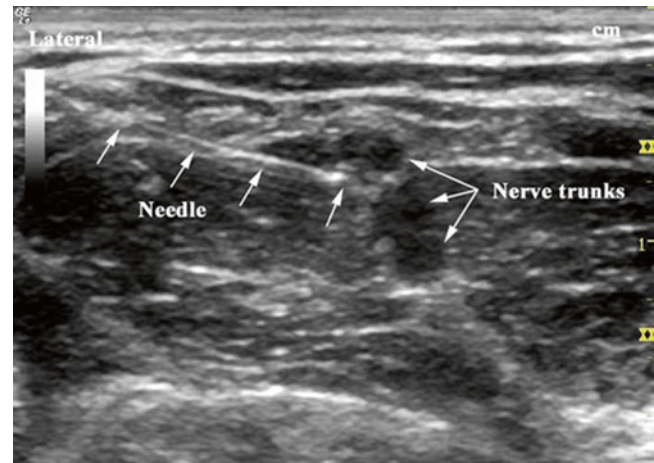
In-plane needle placement during ultrasound-guided interscalene block (With permission from Buckenmaier and Bleckner [71])
